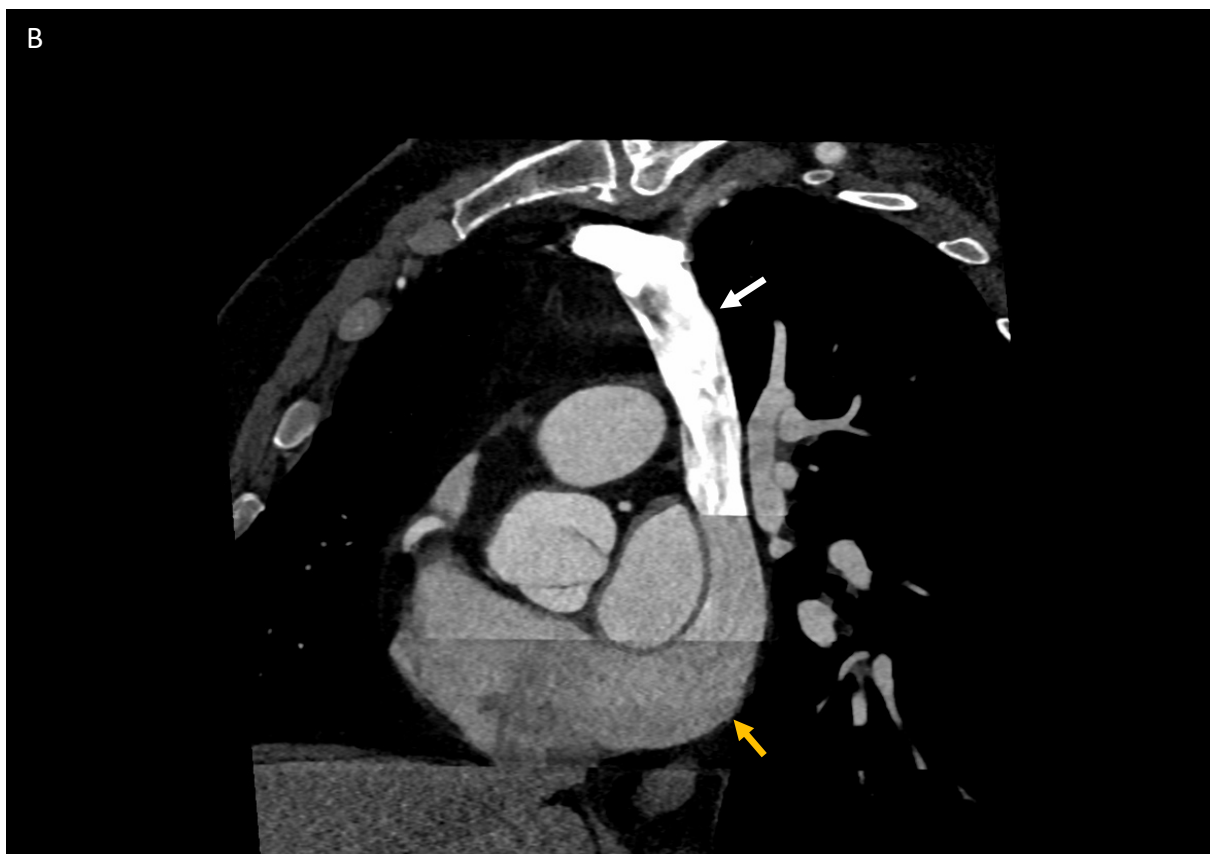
Pre-procedural cardiac CT multi-planar reformat images of the coronary sinus indicating:
